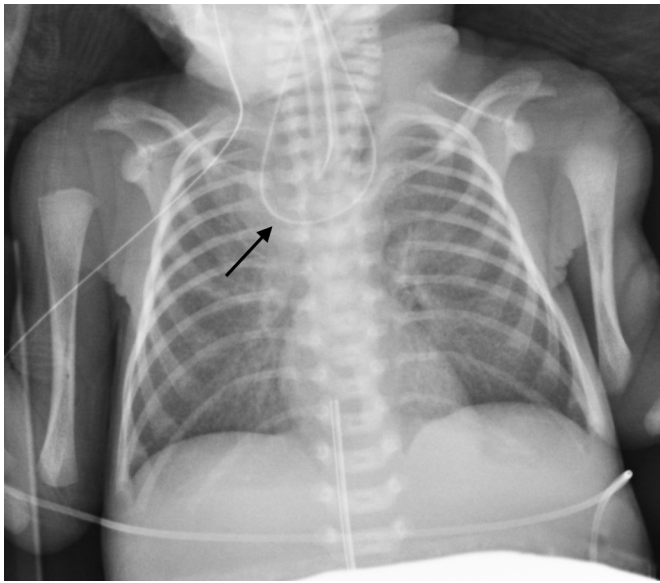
Chest radiograph with coiling of OG tube.
